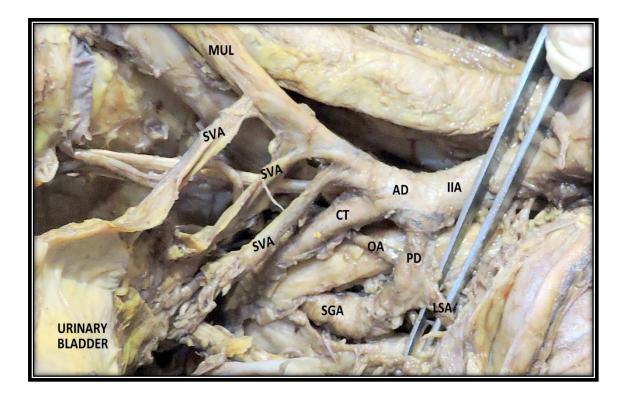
Right pelvic half shows the superior vesical artery (SVA) arises as a three branches from anterior division (AD) of internal iliac Artery (IIA). CT: Common trunk; OA: Obturator artery; SGA: Superior gluteal artery
